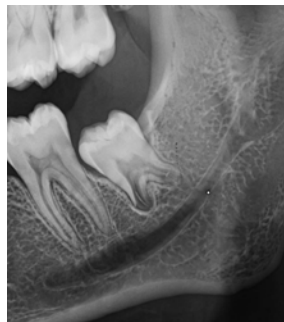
An orthopantomogram shows an impacted mandibular third molar, with two-thirds of the tooth roots having formed. It is important to note that continued development of tooth roots is likely to lead to divergent roots and a closer proximity to the mandibular canal.
